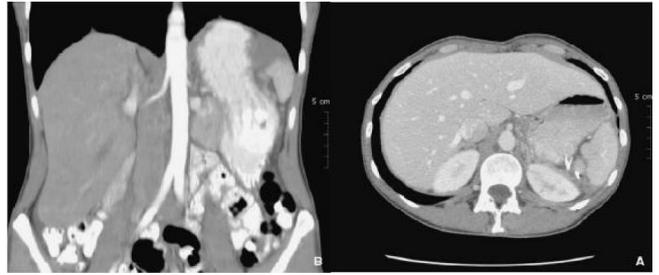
Abdominal CT one year after a partial splenectomy showing the lower polar remainder remains well vascularized.
